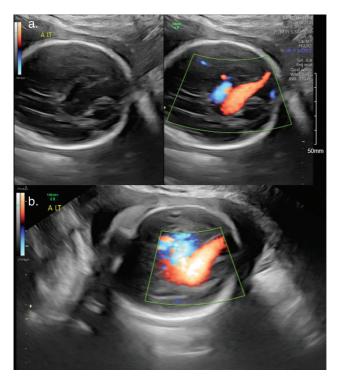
Color Doppler transabdominal ultrasonography at 28 weeks showing an axial view of twin A's head with (a) vein of Galen aneurysmal malformation with comet tail sign and (b) dilated straight sinus.
